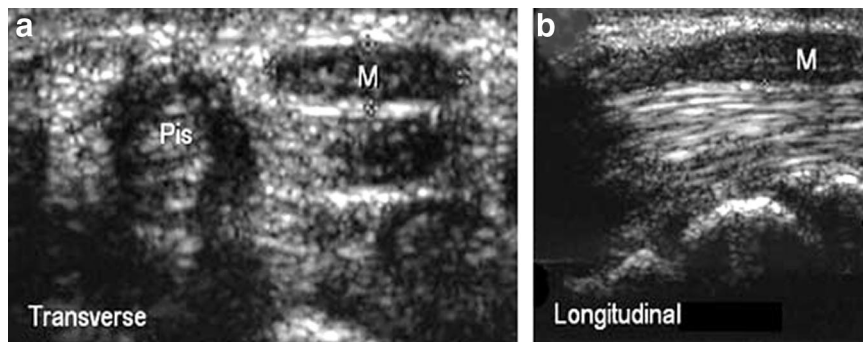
Carpal tunnel syndrome. a, Transverse sonogram of the median nerve (M) at the level of the pisiform bone (Pis). b, Longitudinal sonogram displaying swelling of the median nerve (M) proximal to the retinaculum.
